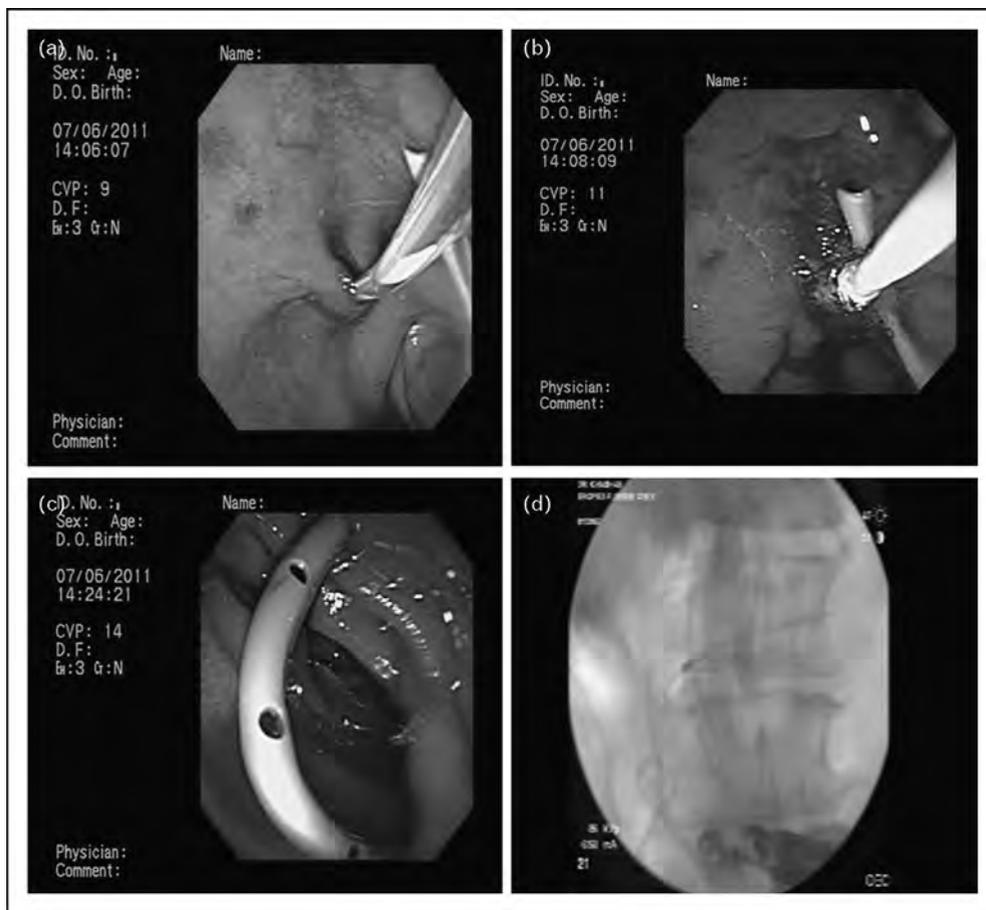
Endoscopic ultrasonography-guided biliary drainage using direct transluminal approach. (a). Choledochoduodenostomy was initially established with puncture of the bile duct with 19-gauge needle and then dilation with an endoscopic retrograde cholangiopancreatography catheter (a sphincterotome in this case). (b) Tract was then balloon dilated. (c) A stent was placed across the choledochoduodenostomy. (d) Fluoroscopic image showing a double-pigtail stent with its proximal end in the bile duct and distal end in the duodenal bulb. In this particular case, a pancreaticoduodenostomy was also established.
